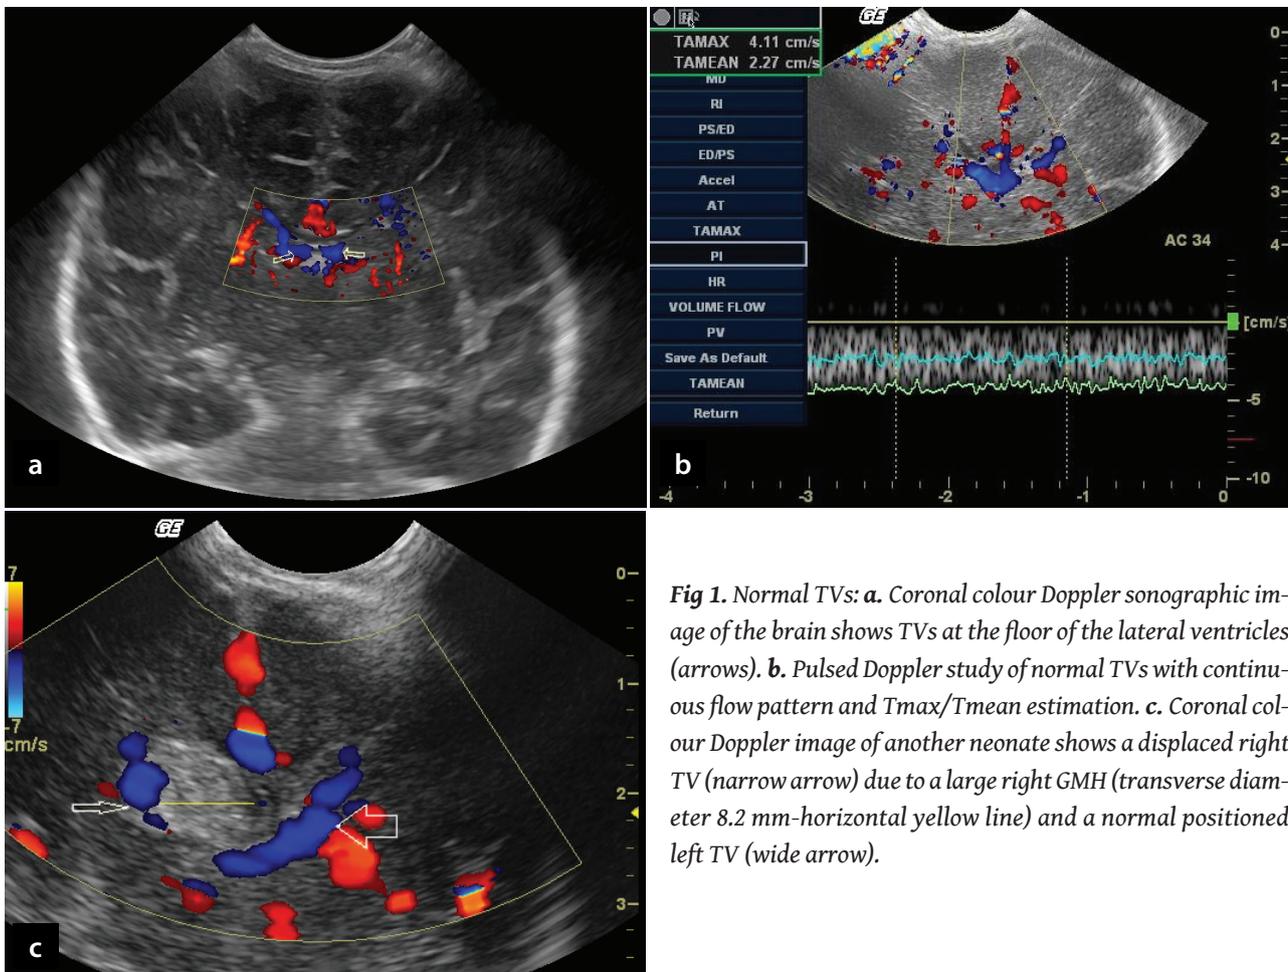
Normal TVs: a. Coronal colour Doppler sonographic image of the brain shows TVs at the floor of the lateral ventricles (arrows). b. Pulsed Doppler study of normal TVs with continuous flow pattern and Tmax/Tmean estimation. c. Coronal colour Doppler image of another neonate shows a displaced right TV (narrow arrow) due to a large right GMH (transverse diameter 8.2 mm-horizontal yellow line) and a normal positioned left TV (wide arrow).
